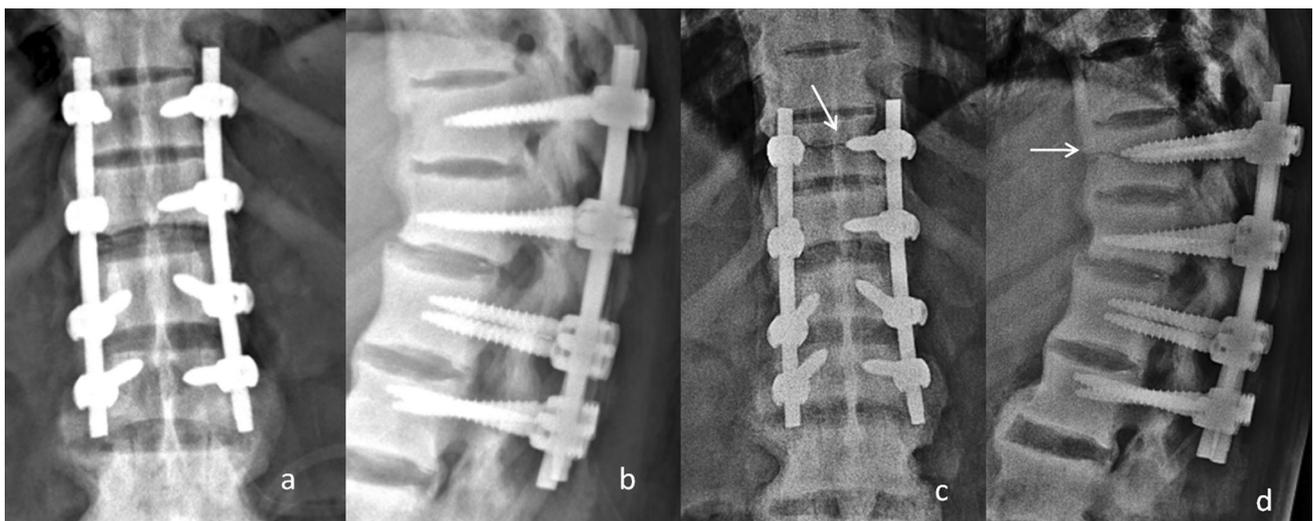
Post-operative radiograph after first surgery. a, b Immediate post-operative radiograph showing satisfactory screw positions with no clear evidence of a fracture line in T11. c, d Radiograph at 1 month showing a faint fracture line at level of upper pedicle screw marked by *white arrow*
